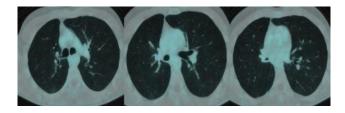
68Ga-DOTANOC PET-CT fusion images.
